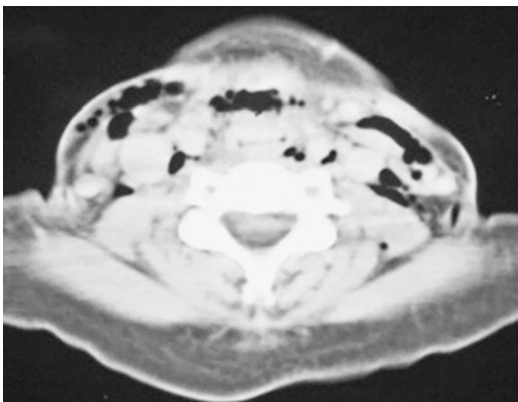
In this CT scan, there is extensive subcutaneous emphysema, and the airway cannot be identified
